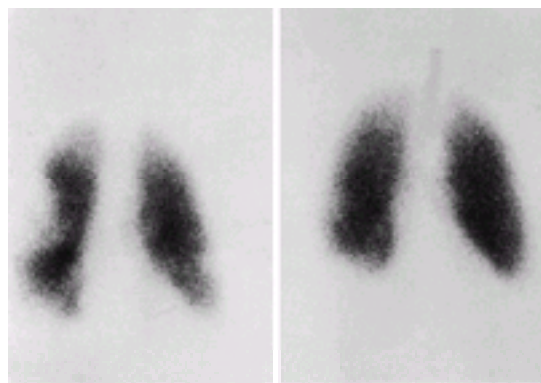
Perfusion–ventilation scintigrams using technetium-99m macroaggregated albumin and krypton-81m gas, respectively. The labelled macroaggregates lodge in the pulmonary capillary bed. The pair of scintigrams shows an unmatched perfusion defect typical of a pulmonary embolus in the right mid-zone.
